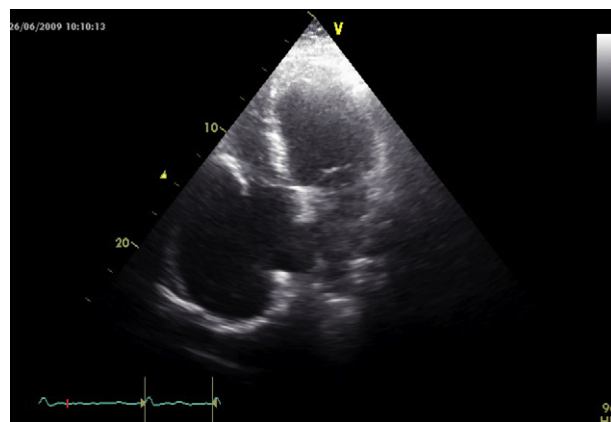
Transthoracic echocardiography in 4-chamber apical view, showing an aneurysmal cavity in the right atrial free wall (11.8 cm × 7 cm), communicating with the atrial chamber through a 4.9 cm orifice, with no apparent tricuspid valve abnormalities.
